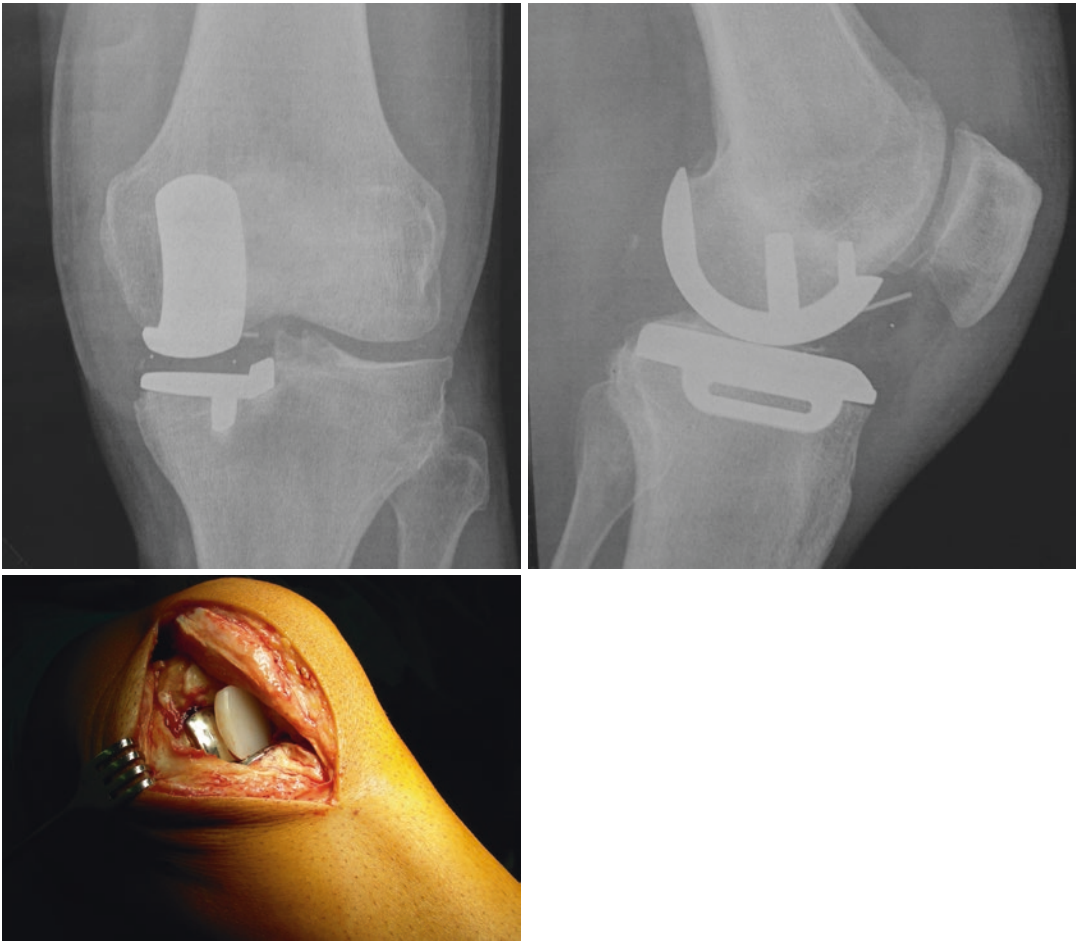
X-ray and intraoperative view of an anterior dislocation of a mobile bearing in medial compartment
